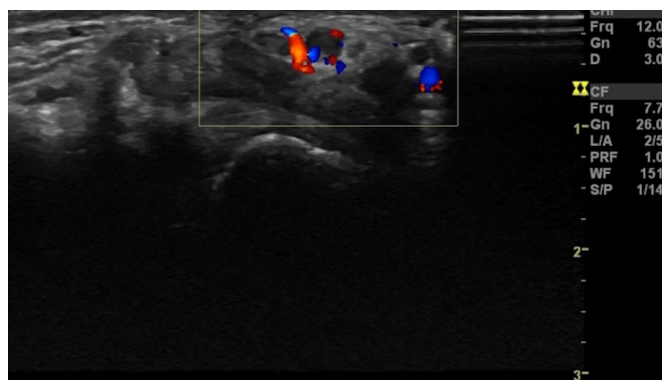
Axial section colour Doppler mapping. Thrombosed persistent median artery. No flow is seen in the lumen (arrow).
